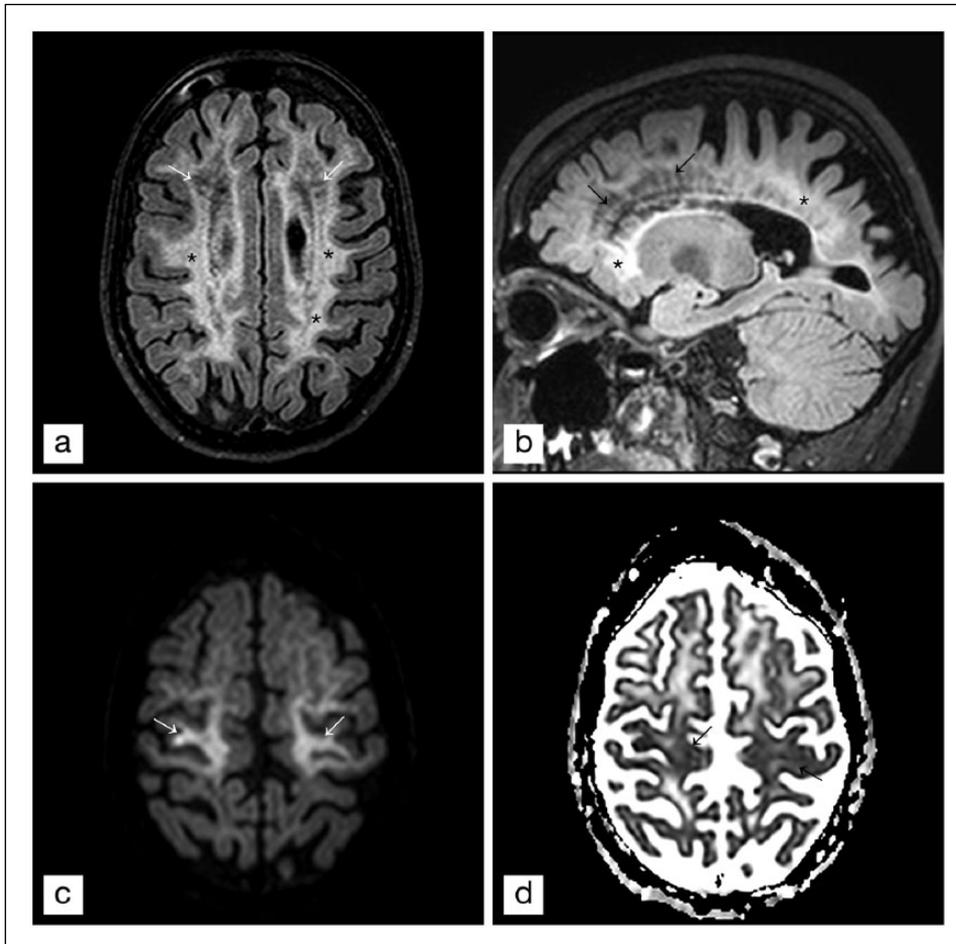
Axial (a) and sagittal (b) FLAIR showing extensive hyperintense white matter changes, partially affecting U fibres (asterisks), cystic degeneration with CSF-similar signal (white arrows) and a radiating pattern of remaining tissue in cystic degenerated tissue (black arrows); DWI showing B1000-hyperintense areas (c) with corresponding ADC signal loss (d) in non-cystic degenerated WM as a correlate of diffusion restriction.
